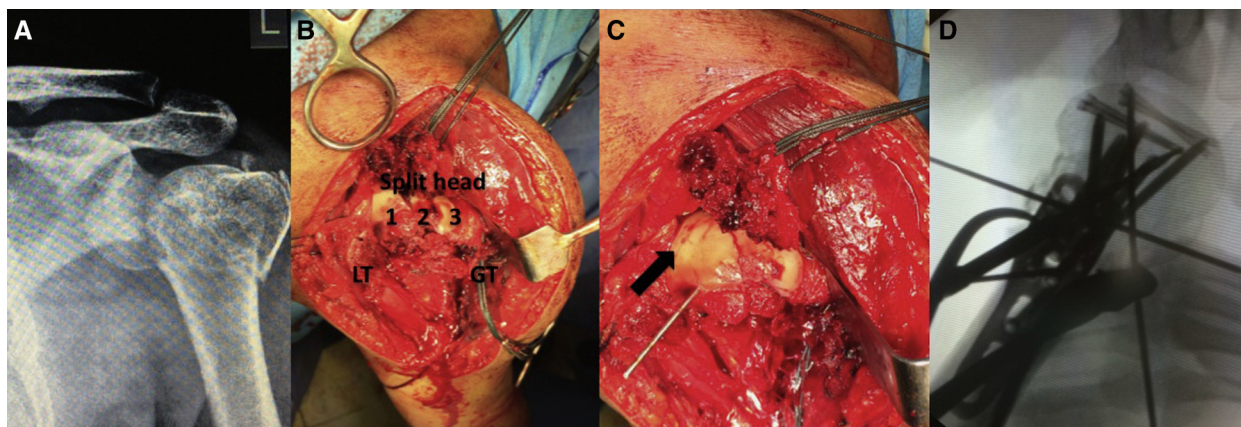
(A) Anteroposterior radiograph showing a complex head-splitting fracture with a subluxated head fragment. (B) Intraoperative image after reduction of the anteriorly subluxated head fragment shows the head split into 3 fragments and the tuberosities (*LT*, lesser tuberosity; *GT*, greater tuberosity) tagged with sutures. (C) After reduction of the head fragments and fixation with headless screws (*arrow*). (D) Axial fluoroscopy image shows the anatomic reduction of the head and tuberosities.
